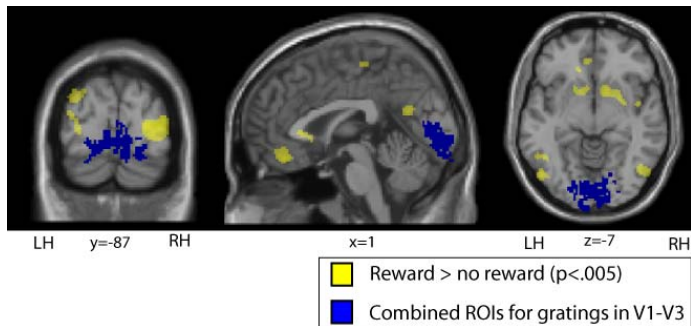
Cortical regions showing increased BOLD signal for rewarded versus non-rewarded trials during the feedback phase of the trial (threshold: $p < .005$ uncorrected) shown in yellow, along with the combined ROIs for the gratings in V1, V2 and V3 for 11 participants (shown in blue), all projected onto coronal, sagittal and axial MRI slices of a T1-weighted canonical brain at the coordinates shown. Note that the regions responding to rewarded trials are anterior and lateral to the regions responding to the gratings within V1-3.
